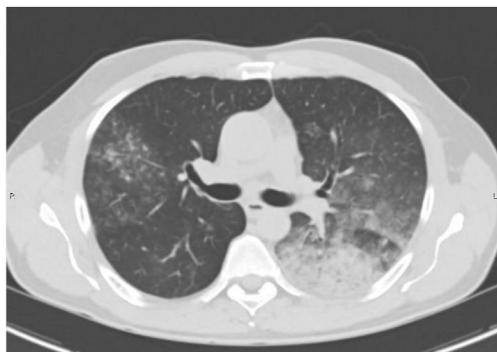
A,B: Axial and coronal views respectively. Second CT scan showing the opacities were more extensive and involved more sub segments of the lungs.
